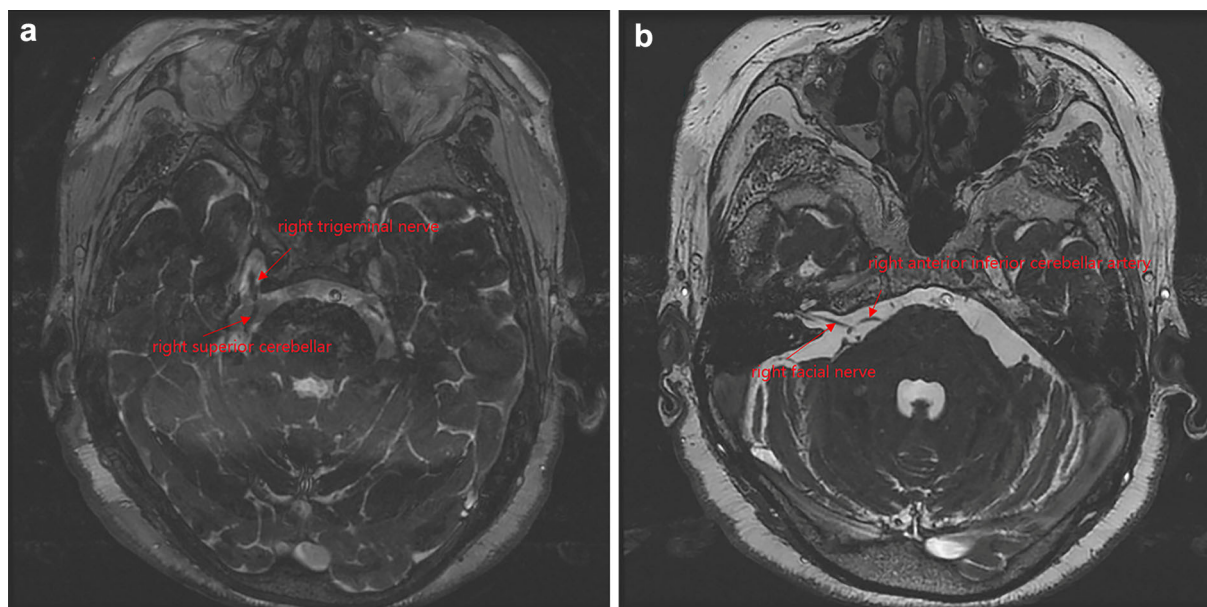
Trigeminal nerve MRI. a The right superior cerebellar artery straddles the trigeminal nerve root; b The right facial nerve root interacted with the anterior inferior cerebellar artery
